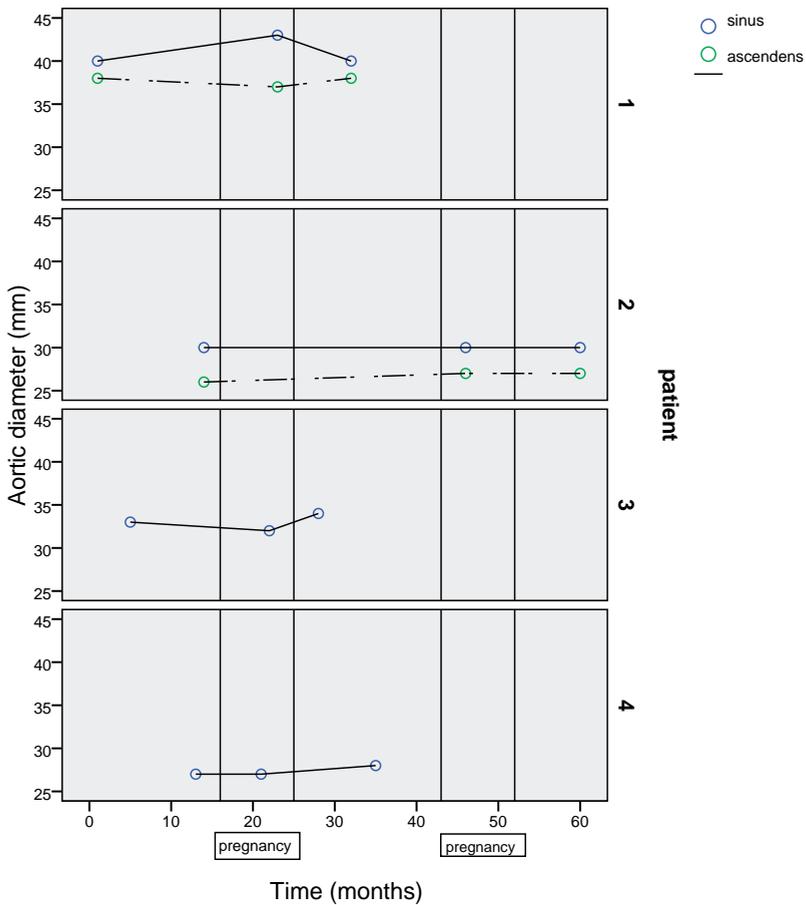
Aortic diameters on echocardiography
